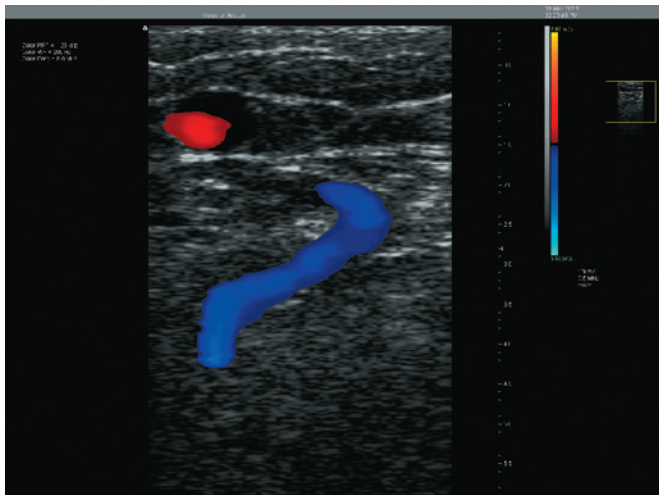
Color Doppler image of a perforator in the calf. (Taken with Terason 2000 system.)
